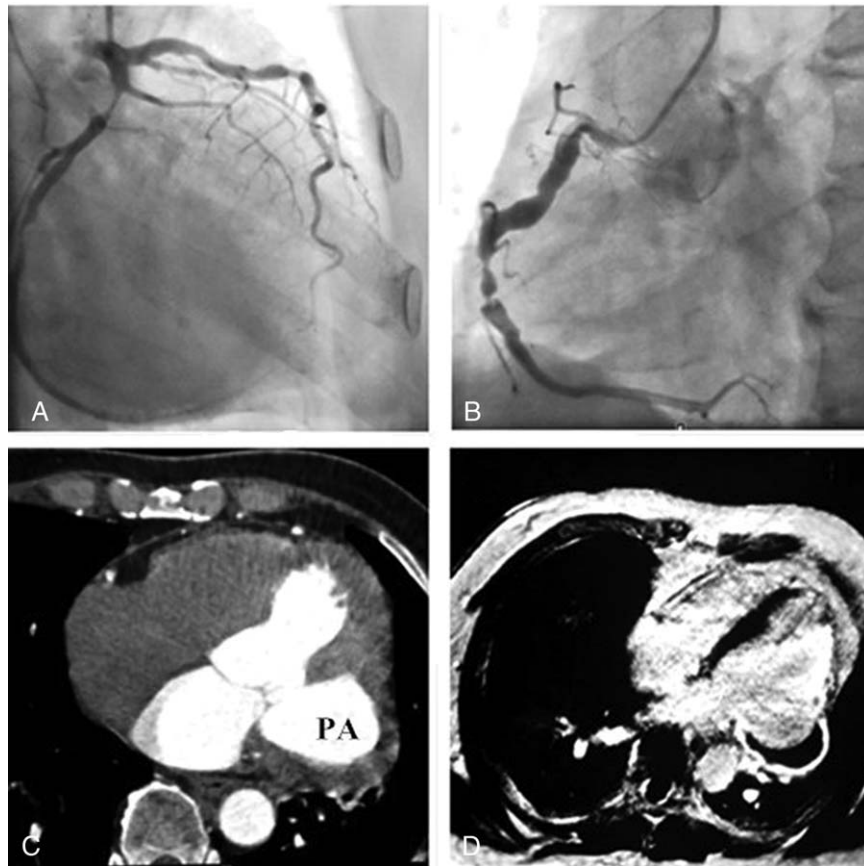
Patient no. 6. (A) Coronary angiography (CAG) shows severe stenosis of the proximal and middle portion of LCX. (B) CAG shows multiple severe stenosis in the middle portion of RCA. (C) CT reveals a pseudoaneurysm with a wide neck. (D) CMR shows a thin wall with full-thickness delayed enhancement and thrombus formation in the pseudoaneurysm. CMR=cardiac magnetic resonance, CT=computed tomography, LCX=left circumflex artery, PA=pseudoaneurysm.
